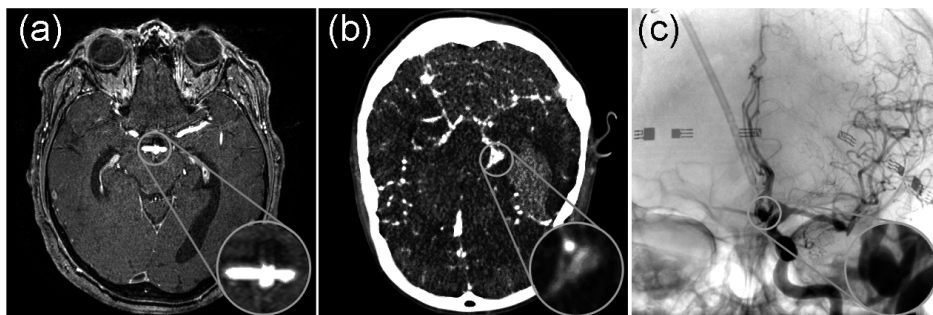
Image modalities to visualize cerebral aneurysms. (a) MRA, (b) CTA. (c) DSA. Aneurysm location was amplified to enhance the visualization.
